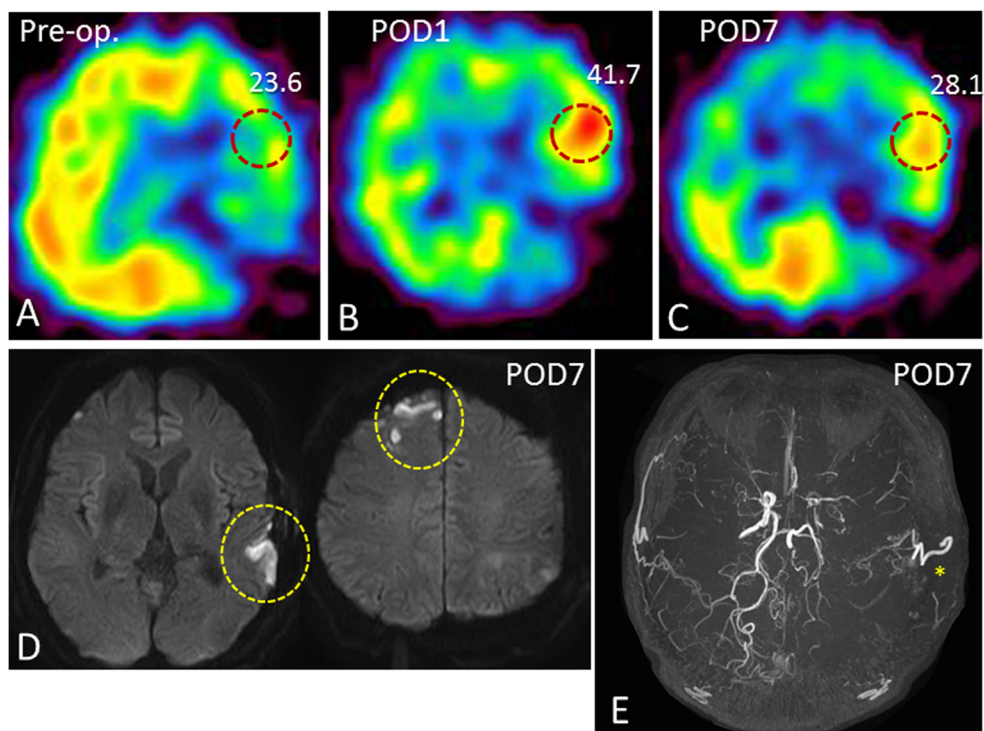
a–c Temporal profile of ^{123}I -IMP-SPECT images a before surgery, b 1 day after surgery, and c 7 days after surgery. Quantitative local CBF values are shown in a–c (dotted circles). Pre-operative SPECT showing decreased CBF in the left frontotemporal lobe; direct bypass surgery resulted in prominent hyperperfusion at the site of anastomosis 1 day after surgery, which improved 7 days after surgery. d Postoperative diffusion-weighted MRI demonstrating acute cerebral infarction at the right frontal lobe and left temporal lobe (yellow dotted circles) 7 days after surgery. e Postoperative MRA showing the patent left STA-MCA bypass (asterisk in e) 7 days after surgery. Pre-op means pre-operative; POD means postoperative day
